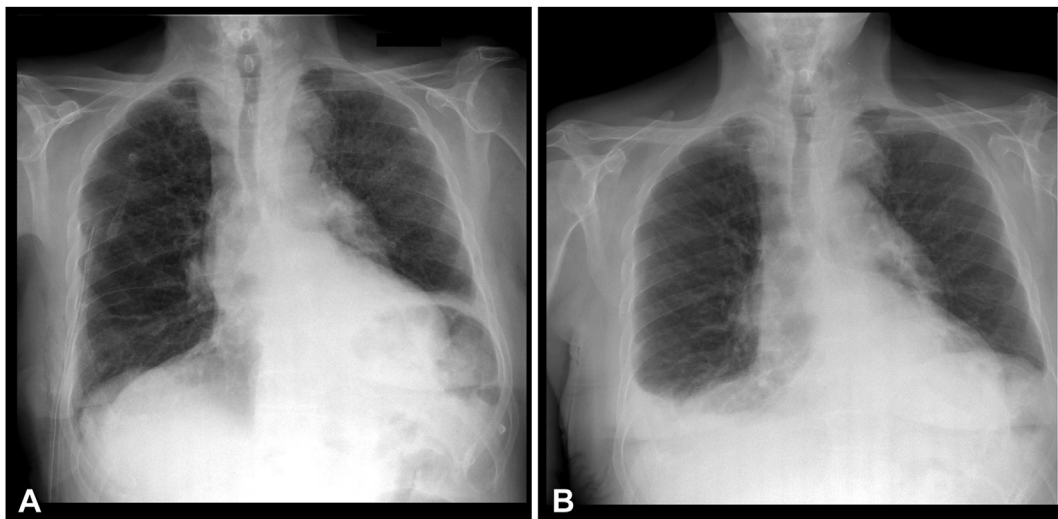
Chest x-ray examination at follow-up. A, After 3 days. B, After 9 days.
